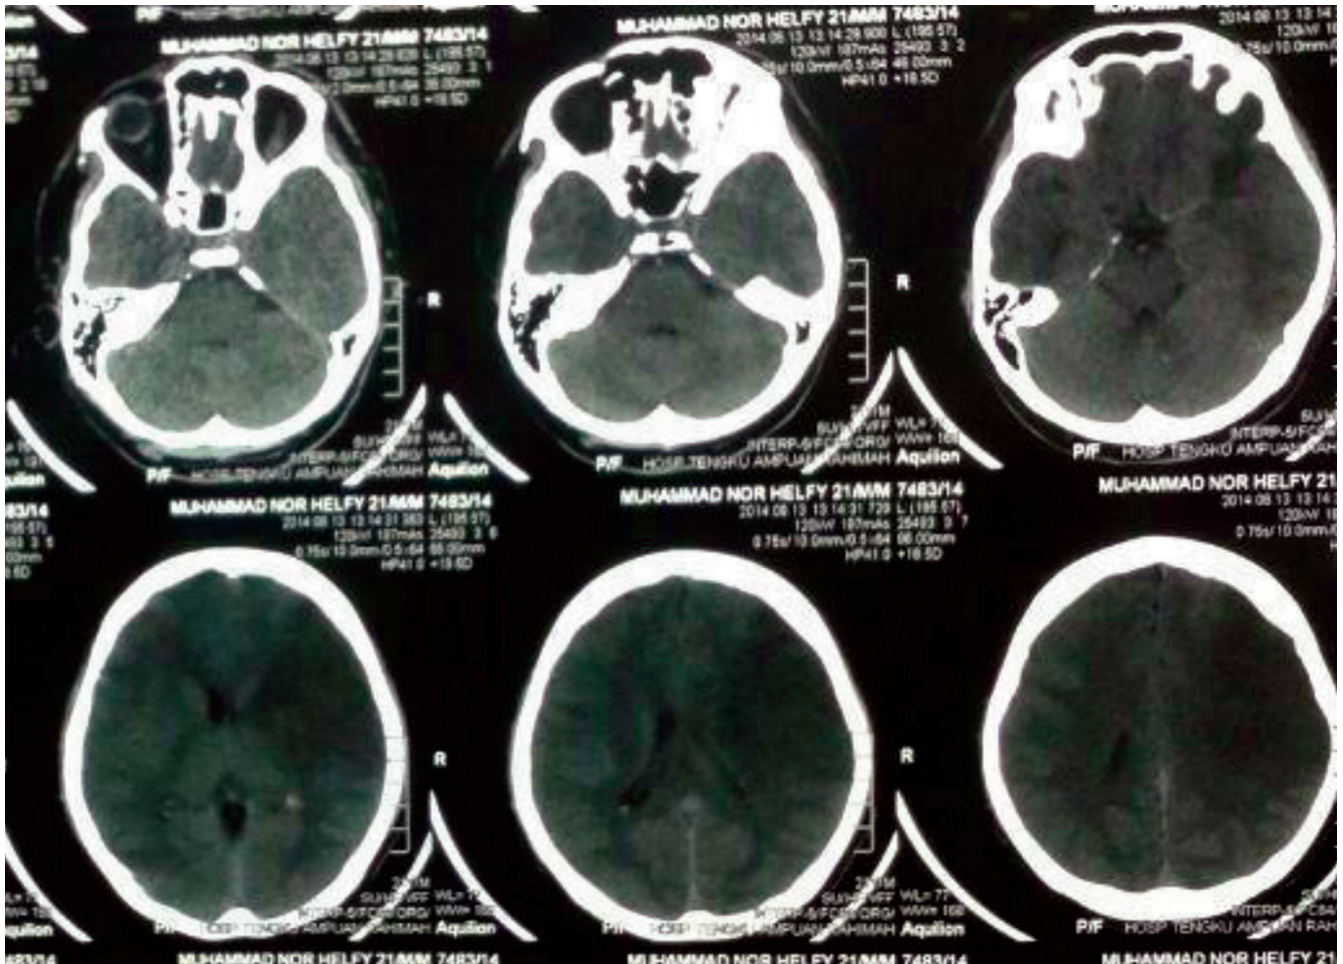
Subsequent CT Brain showing left MCA Infarct
